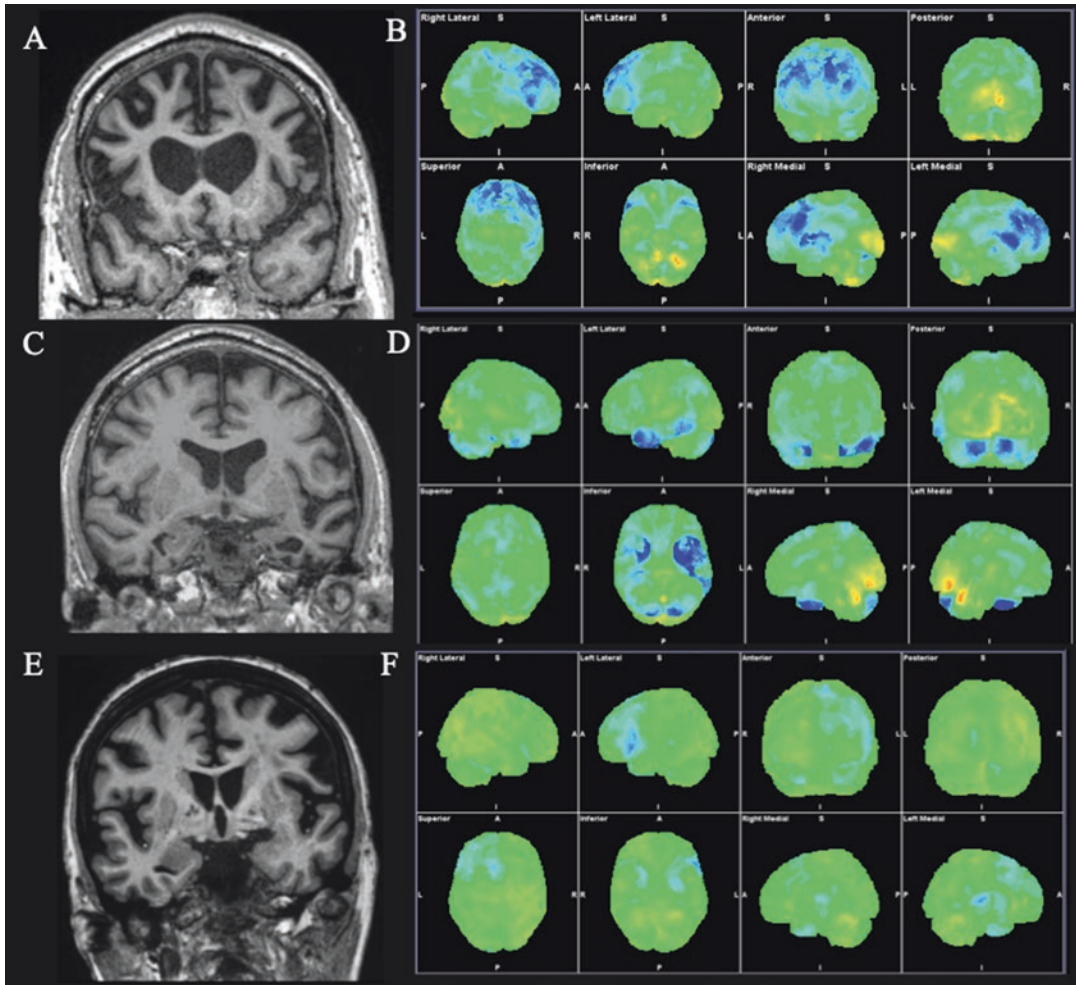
T1-weighted MRI images and FDG-PET surface projections obtained in clinical practice in individual patients with typical FTL D clinical syndromes. In bvFTD, atrophy (a) and hypometabolism (b) are observed in bilateral dorsolateral and dorsomedial prefrontal, anterior and mid-cingulate, and insular cortices. BvFTD is heterogeneous, and patients often present with orbitofrontal or
